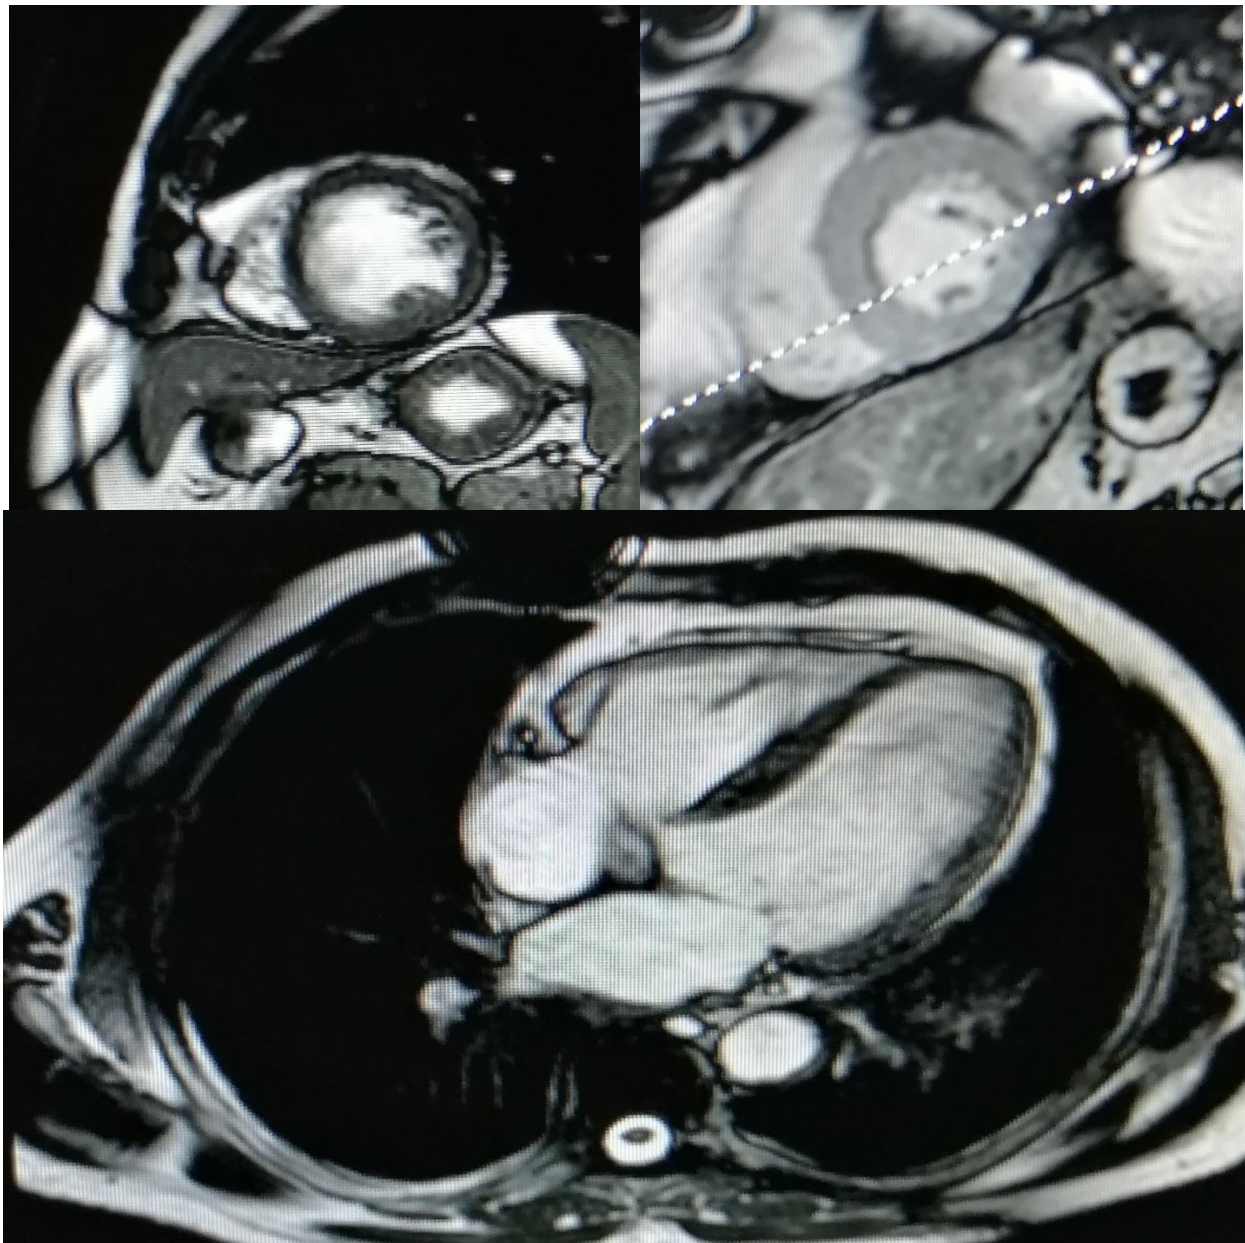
CMR study in subject (17) after DAA. Upper left: Short axis cine image. Upper right: PSIR sequence in short axis with no LGE. Bottom: Apical 4 chamber cine image.
